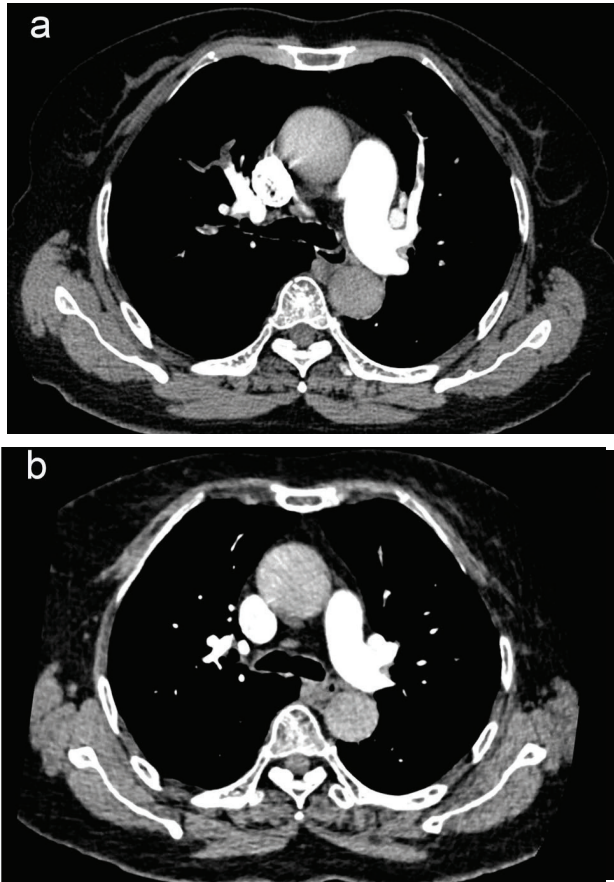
Comparison of computed tomography pulmonary angiography. a) Image on admission showing bilateral subsegmental and segmental pulmonary embolism. b) Image at 3 months after discharge showing no pulmonary embolism.
